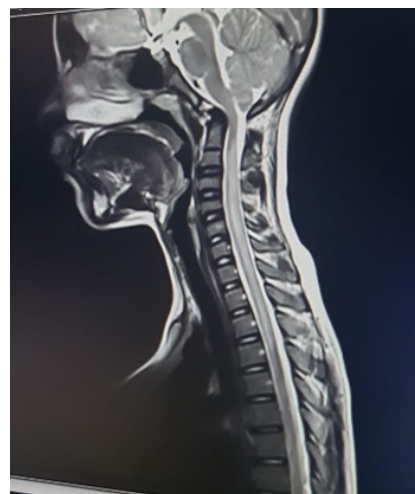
Reduction in cord swelling as compared to previous MRI
